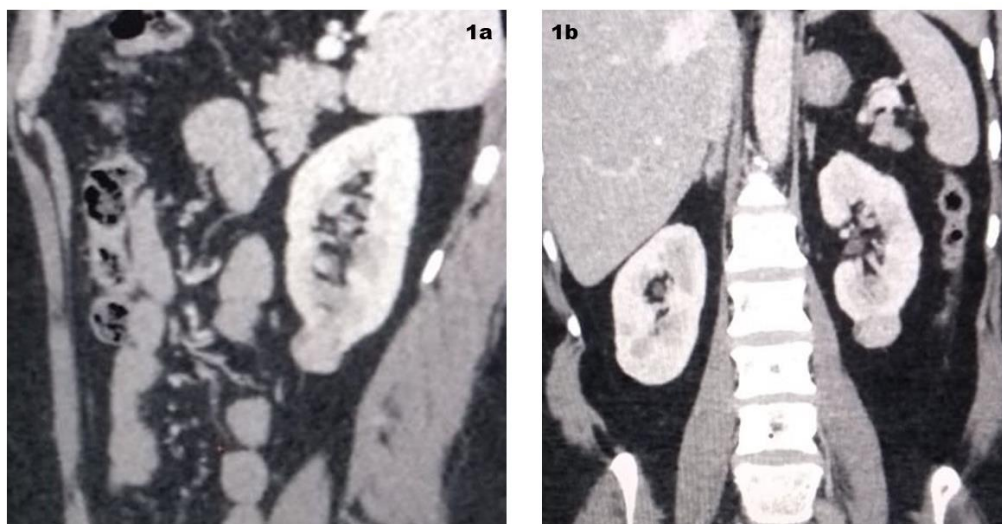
CT scan in a 40-year-old female shows Lt. sided exophytic lower polar renal mass (T1a N0 M0).
